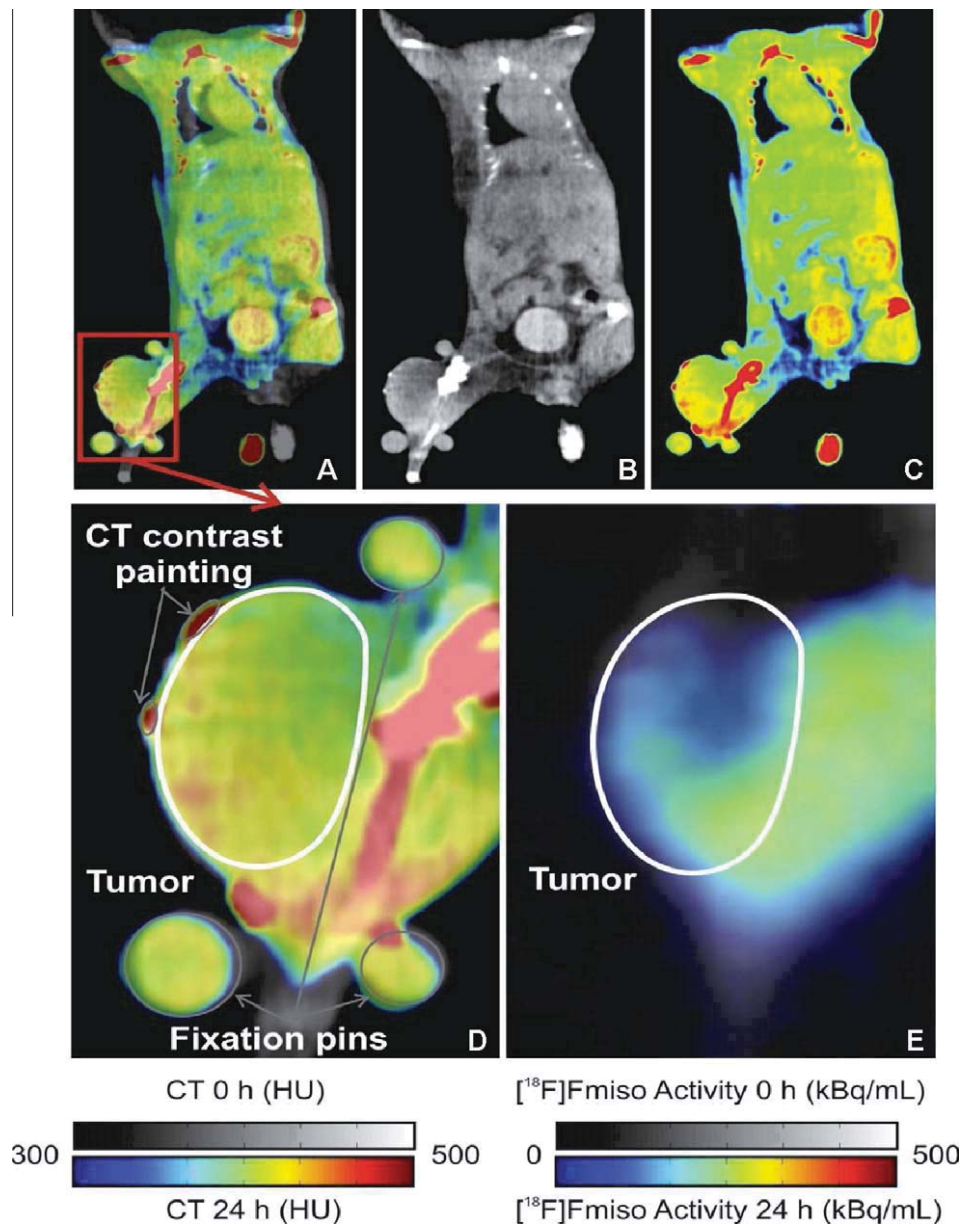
Example of a co-registration between 0 and 24 h for FaDu tumor # 7. (A) Shows the fusion of the two serial CT images (0 and 24 h), (B) is the CT image at 0 h (gray scale) and (C) is the CT image at 24 h (color scale). Detailed views of the acquired over-lapped CT (D) and PET (E) images of the investigated tumor area are represented in the bottom panels. The gray contours indicate the external fixation pins and tumor skin painted with CT contrast solution, the white contour denotes the investigated tumor area.
